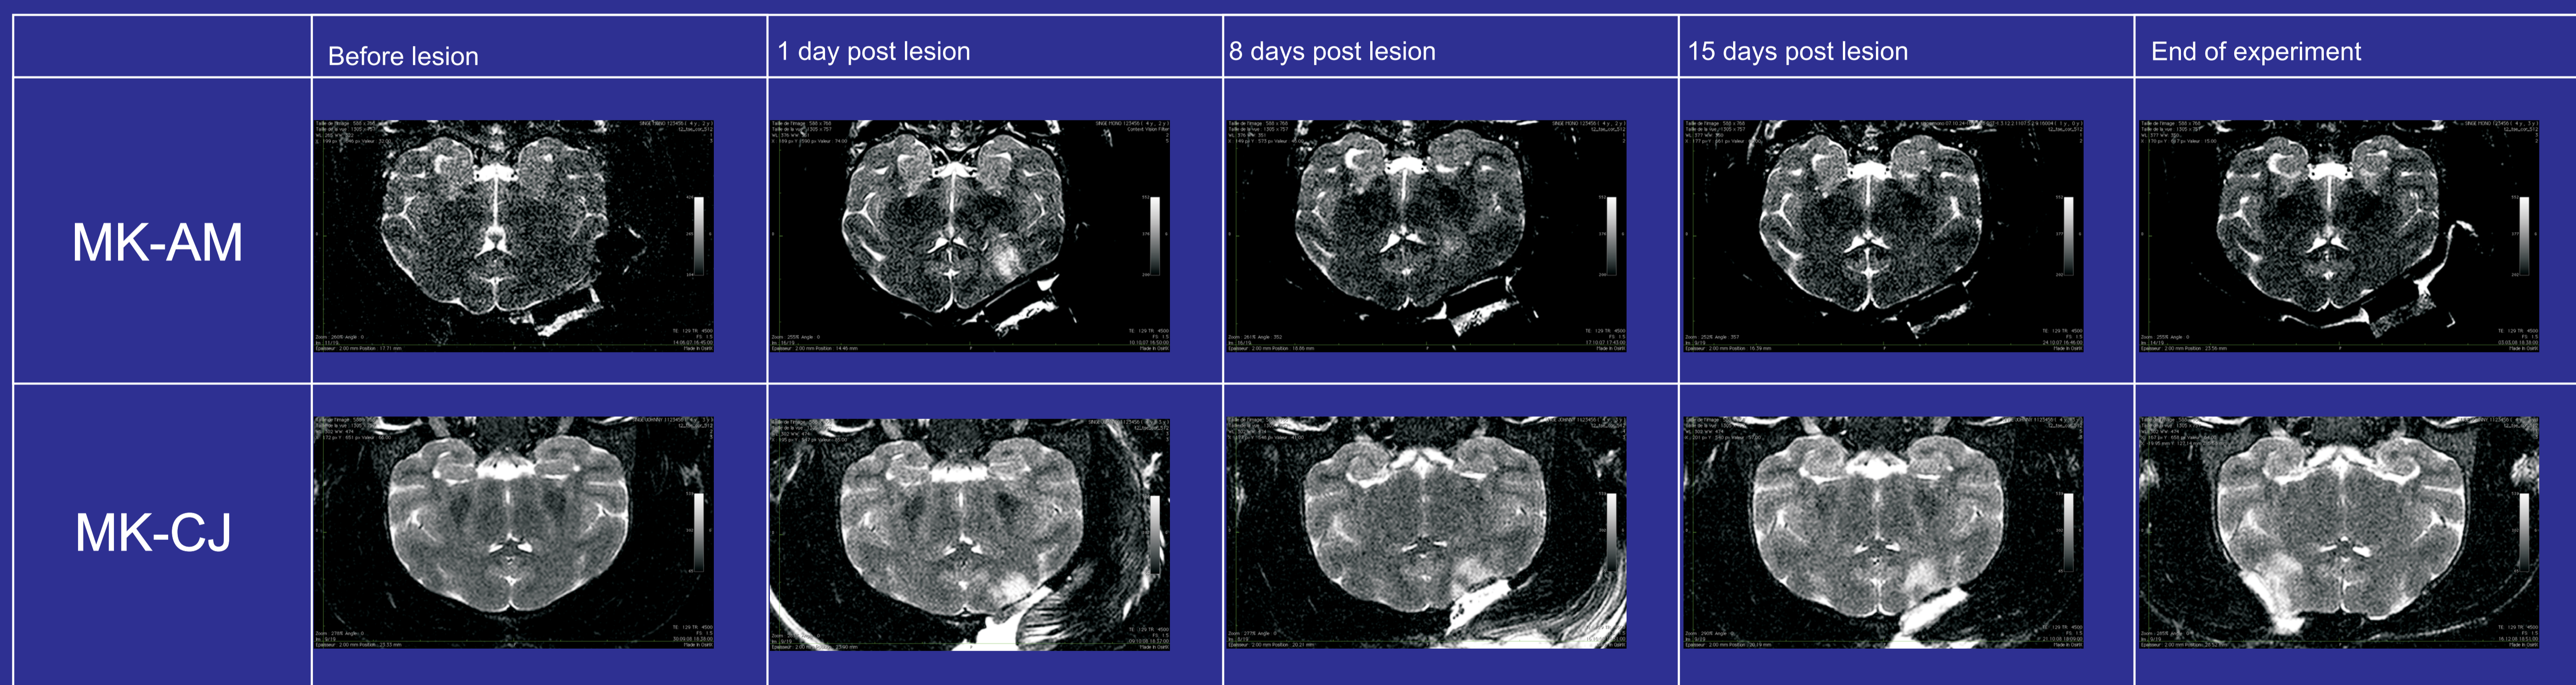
MRI of coronal sections at the same location along the different sessions showing the evolution in time of the hypersignal in Mk-AM (upper row) and Mk-CJ (lower row) on the parasagittal axis
